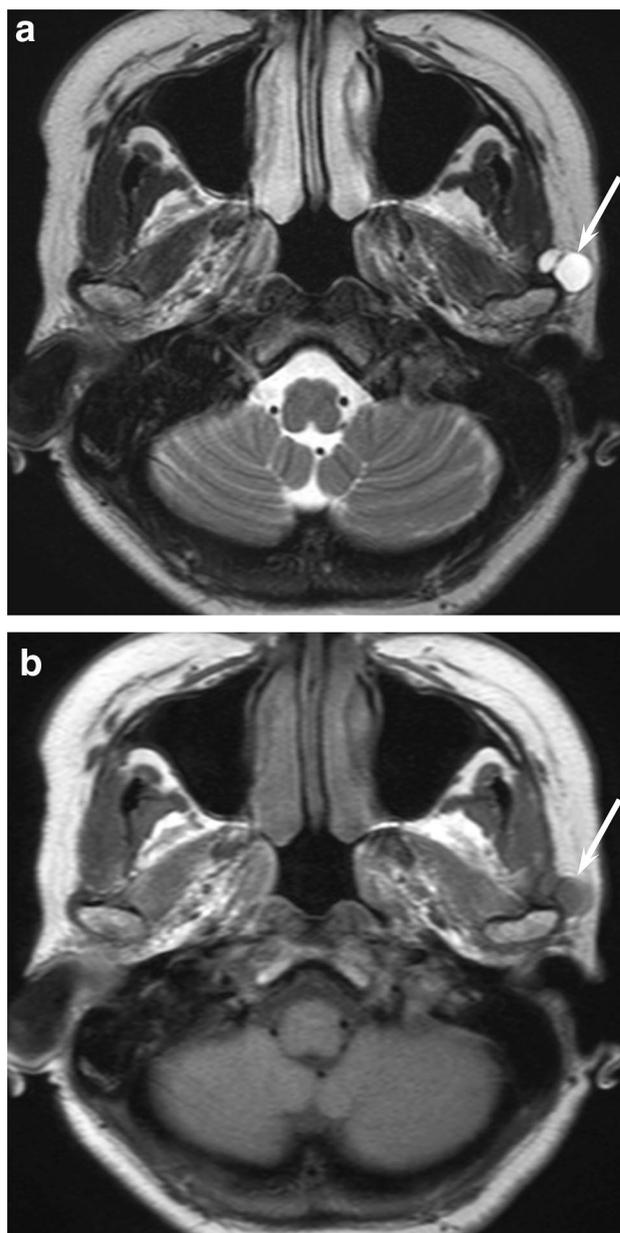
A 54-year-old woman with salivary duct cyst. a T2-weighted image shows a thin-walled bilocular cystic lesion (arrow) in the left parotid gland. b T1-weighted image shows a hypointense cystic lesion (arrow)
